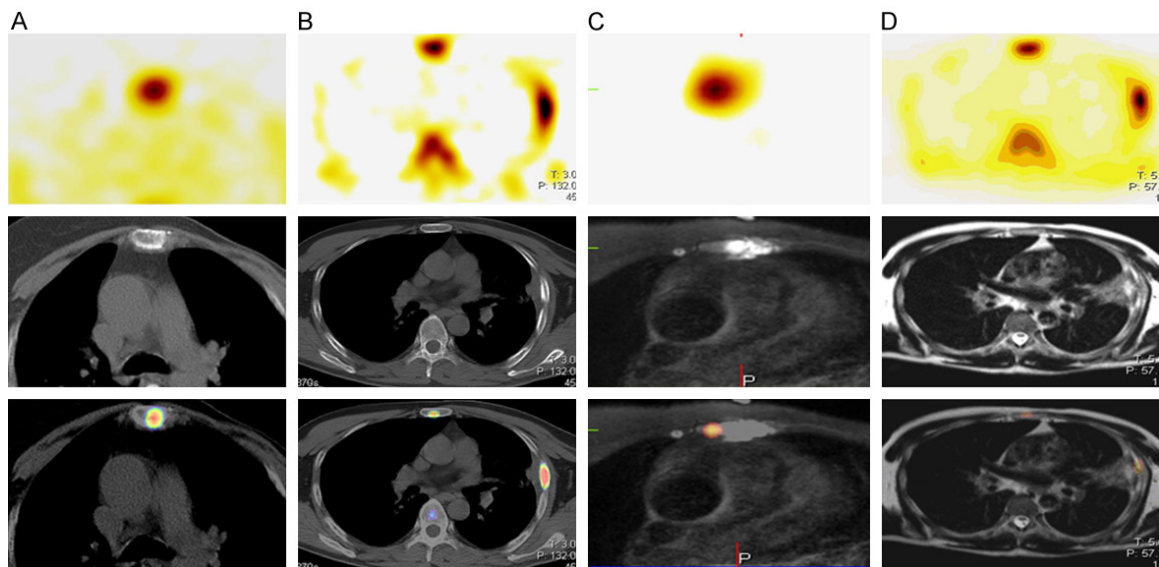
SPECT/CT and SPECT/MRI images in sternum and rib. A. SPECT/CT image in left sternum. B. SPECT/CT image in left rib. C. SPECT/MRI image in left sternum. D. SPECT/MRI image in left rib.
